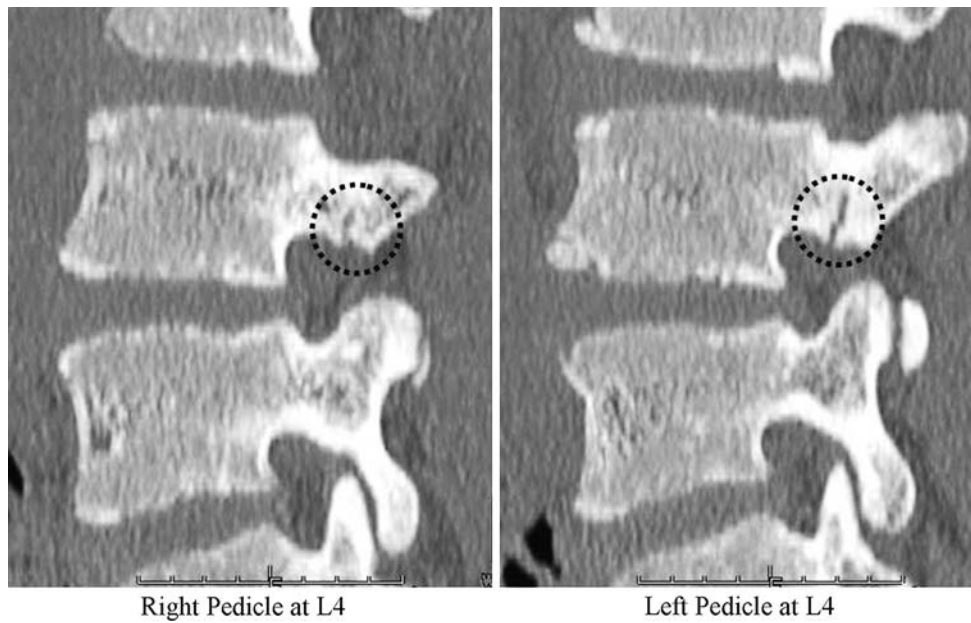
CT scan of the L4 vertebra showing fractures in both pedicles
